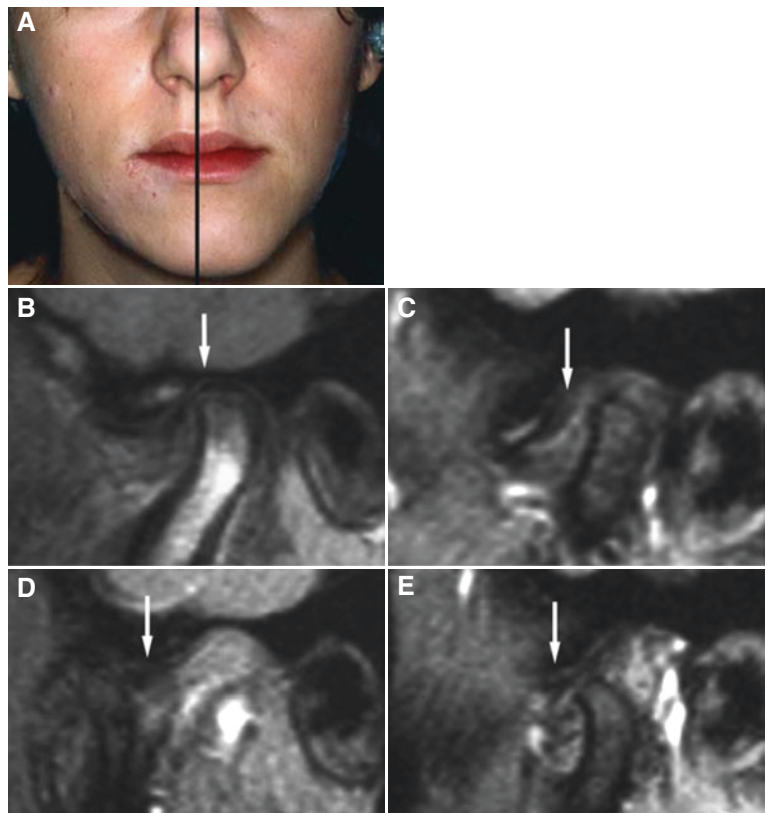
Condylar hypoplasia and facial asymmetry without history of trauma. (A) Clinical photograph shows mandible deviating to the patient's left side. (B, D) Oblique sagittal MRI of the right joint shows normal disc (*arrow*) and normal bone, also in open-mouth image (D). (C, E) Oblique sagittal MRI of the left joint shows anteriorly displaced disc (*arrow*), also in open-mouth image (E). The left condyle is small but otherwise normal, and translation is restricted compared to the right joint (courtesy of Drs. A. Isberg and P. E. Legrell, Umea University, Sweden)
